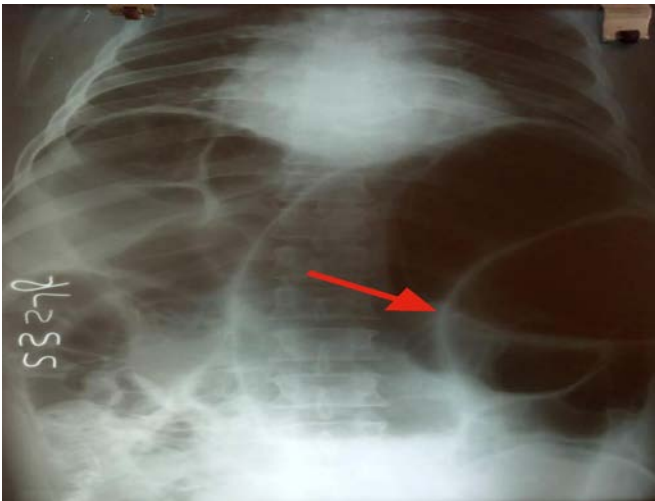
Erect X-Ray abdomen exhibiting 'Coffee bean' sign suggestive of torsion of bowel.
